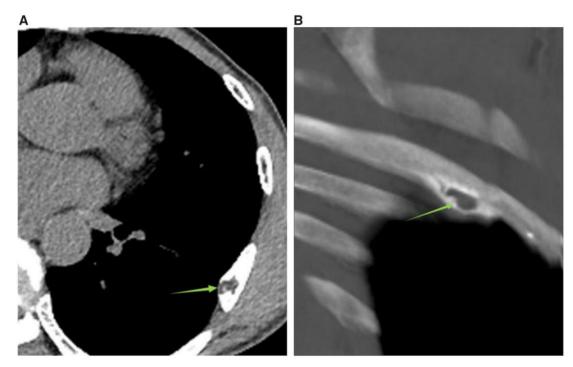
(A) CT showing lesion with a expansile bone and focal cortical disruption within the rib. Fat-dense areas in the lesion. (B) The location of the intraosseous hibernoma was visualized by three-dimensional reconstruction of the rib.
